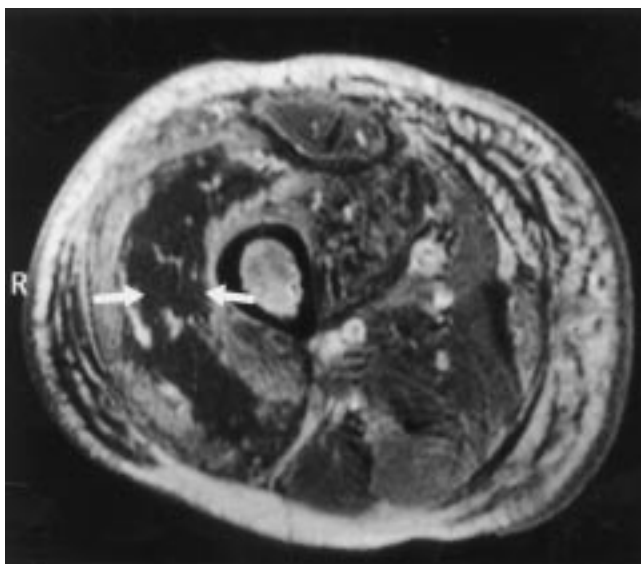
Transverse T1-weighted SE image obtained after intravenous injection of contrast material shows a central dark, non-enhanced area inside the right enlarged quadriceps muscle with surrounding enhancement. Linear enhanced signal infiltrates (arrows) are present through the dark core and tissue planes are preserved. R=right
